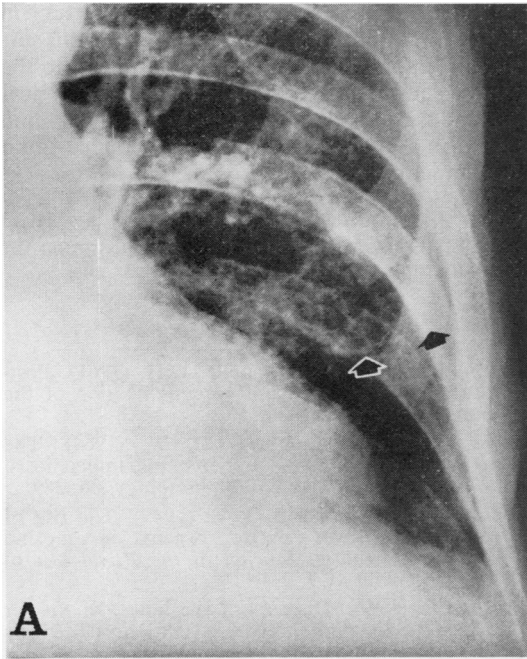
(A) Chest radiograph of left basal area to show fine line shadow (arrows) taken to be pulmonary scar due to old pulmonary infarct.
